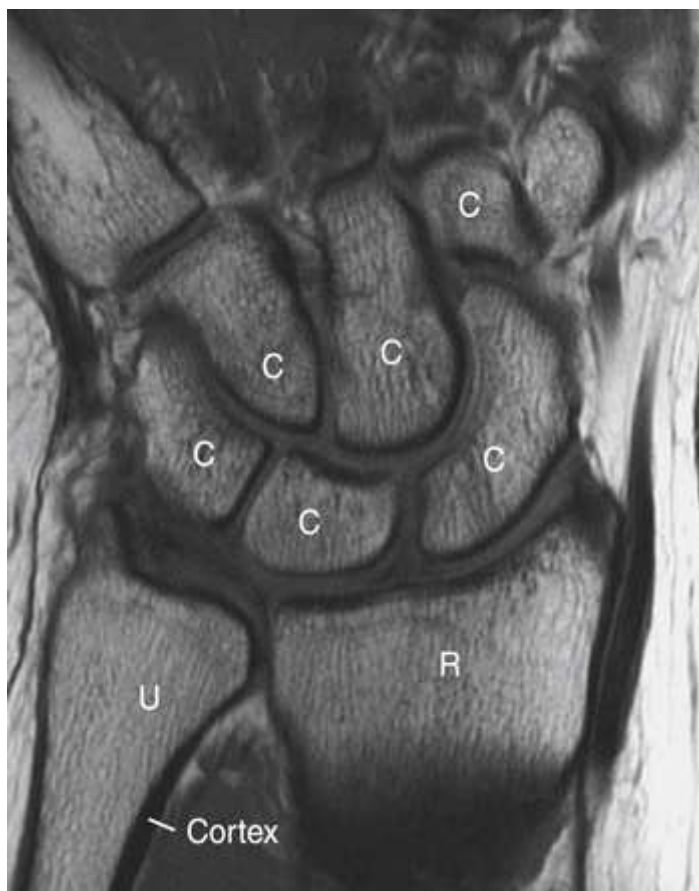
T1-weighted coronal MRI of the wrist using a surface coil to improve visualization of superficial structures. Marrow within the carpal bones (*C*), radius (*R*), and ulna (*U*) has high signal as a result of its fat content. A thin black line of low-signal cortex surrounds the marrow cavity of each bone, and trabecular bone can be seen as low-signal detail interspersed within marrow.
